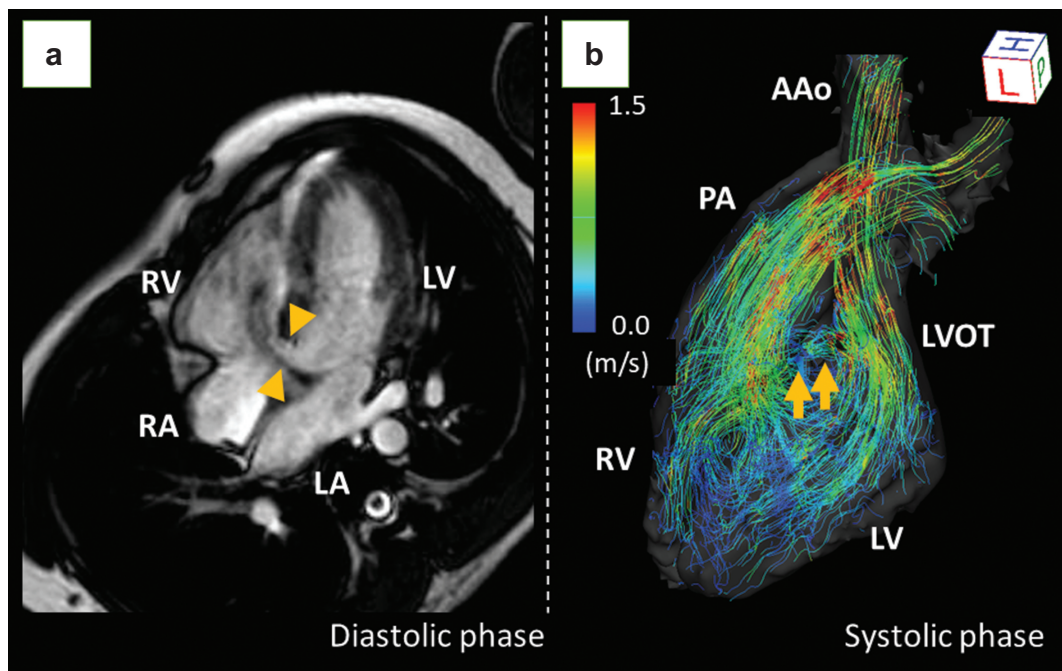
A case of VSD. Four-chamber cine MRI revealed a large VSD of 10 mm (a, arrowheads). The streamlined image of 4D flow MRI clearly depicts the flow jet of the VSD from the LVOT to the RV, as well as the laminar flow in the ascending aorta and the pulmonary artery (b, arrows). The pulmonary to systemic blood flow ratio ($Q_p:Q_s$) was 1.62:1. Although he had no symptoms, surgical repair was performed due to an elevated mean pulmonary arterial pressure of 25 mmHg with reduced right ventricular ejection fraction of 37%. AAO, ascending aorta; LA, left atrium; LV, left ventricle; LVOT, left ventricular outflow tract; PA, pulmonary artery; RA, right atrium; RV, right ventricle; VSD, ventricular septal defect.
